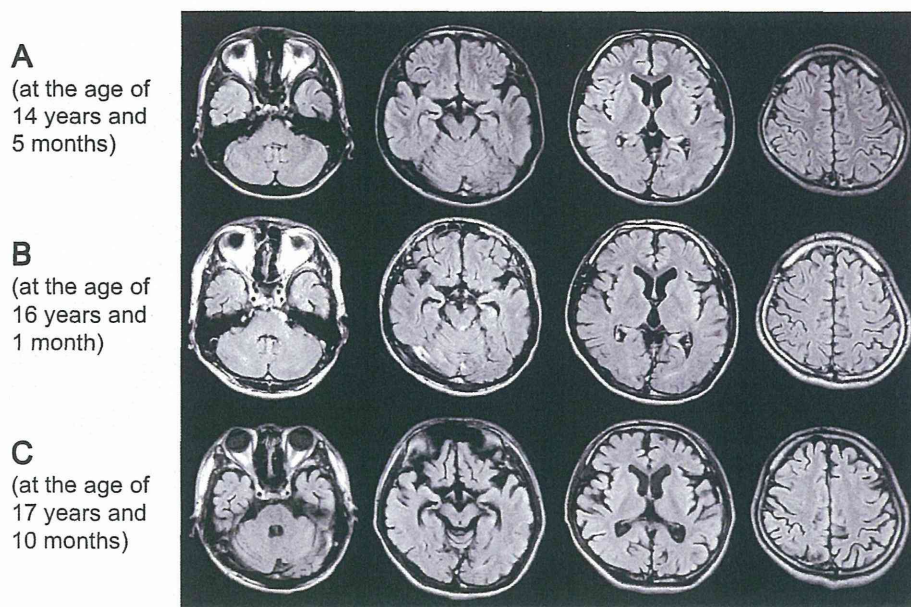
Serial brain MRI of the patient (FLAIR image, axial view). A (top row), B (middle row) and C (bottom row) show MRI findings obtained at 14 years and five months, 16 years and one month and 17 years and 10 months of age. Diffuse brain atrophy became more evident with age. Brain atrophy was more obvious in the inferior parts of the temporal lobe, cerebellum and brainstem region.
